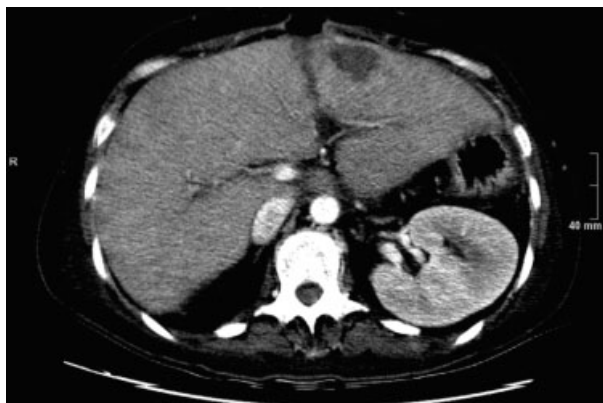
CT scan: Nocardiosis of the liver.
